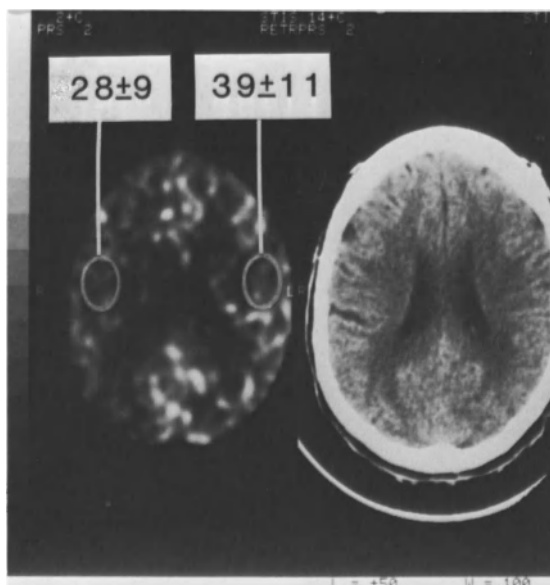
a. This 63-year-old man had frequently recurrent episodes of left hand weakness and numbness which occurred while sitting or standing. The baseline CBF study demonstrated reduced flows within the right hemisphere despite absence of a CT-defined abnormality
